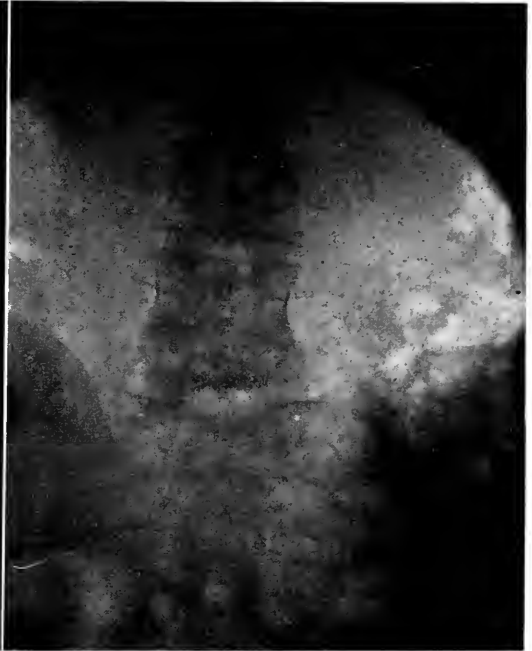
ROENTGENOGRAM. METASTASIS OF CARCINOMA OF THE FIFTH LUMBAR VERTEBRA AFTER APPLICATION OF RADIUM. Shows new bone formation.
